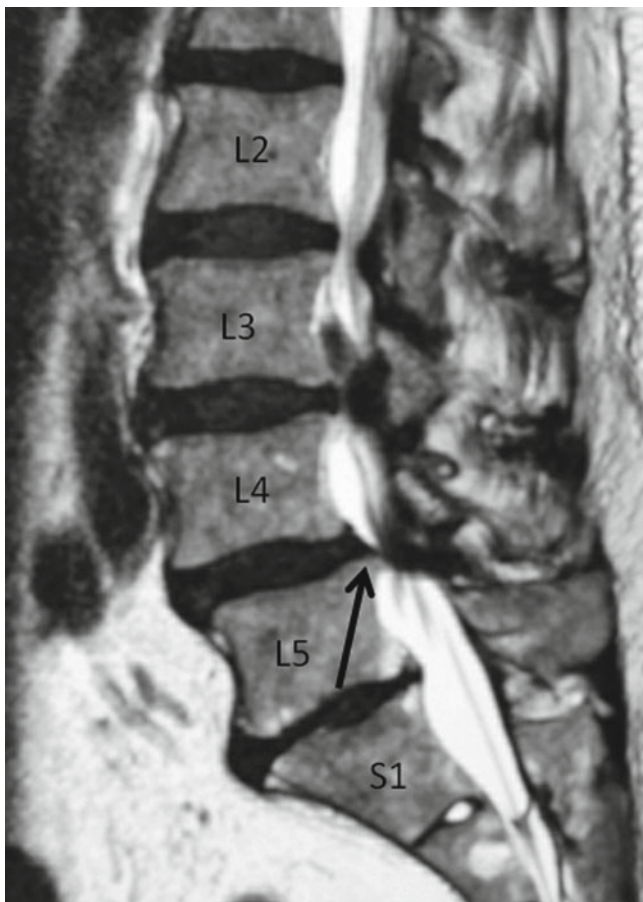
Sagittal T2-weighted lumbar MRI image demonstrating moderate L2–3 and severe L3–4 and L4–5 stenosis. In addition, there is a slight degenerative spondylolisthesis at L4–5, where the L4 vertebral body is located slightly anterior to the L5 vertebral body (*black arrow*)
